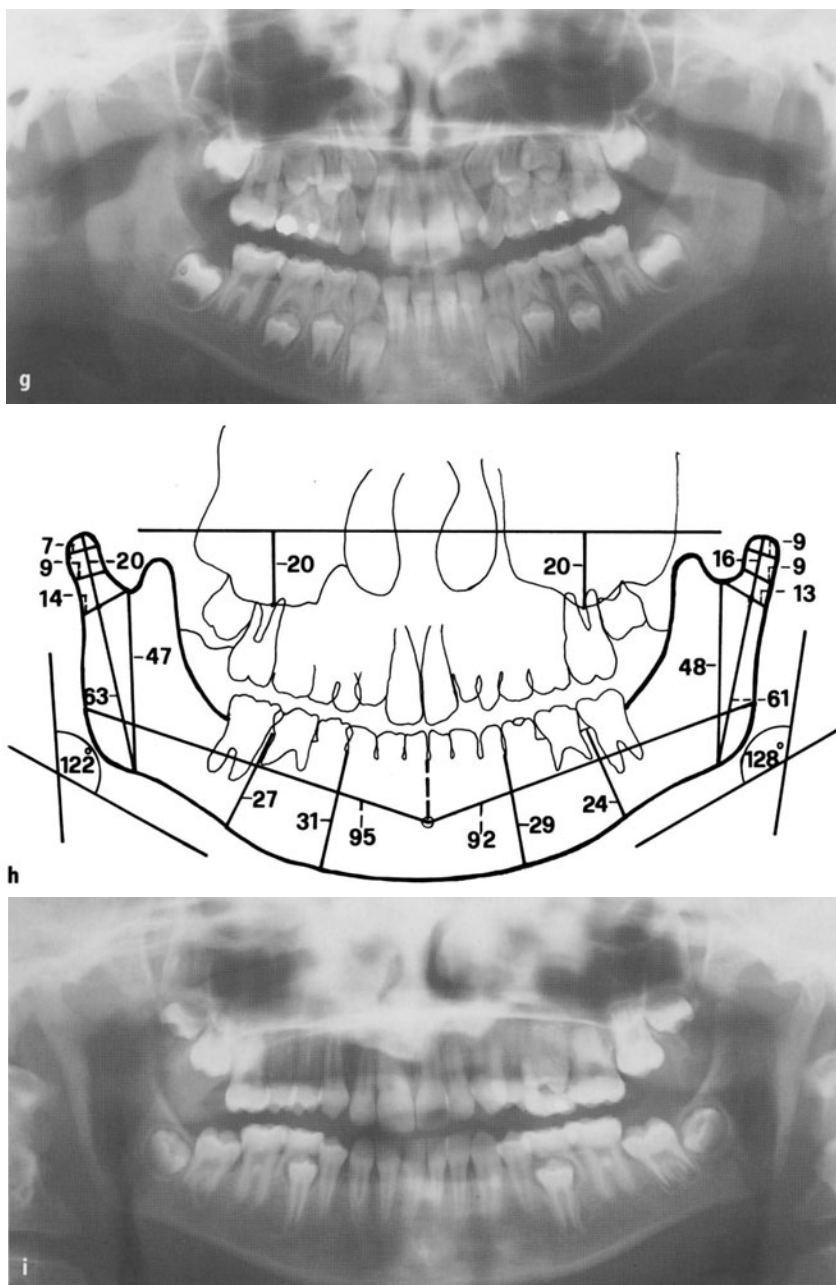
Unilateral hypoplasia of the condyle of uncertain aetiology. a, b At the age of 8 years a slight facial asymmetry is noticeable and the midline of the lower teeth is to the left by 2 mm. c, d At the age of 11 years the asymmetry of the face and of the occlusion is more pronounced. e, f At age 13 years the girl's appearance now clearly shows the consequences of hemimandibular hypoplasia, including an oblique occlusal plane and an ipsilateral hypoplasia of the zygomatic complex. g The panoramic view at age 8 years does not permit a clear diagnosis right away. h The measurements of the tracing of the panoramic radiograph, taken at age 8 years (Fig. 21g) detect a slight shortness of the left horizontal and ascending rami. i The panoramic view at age 11 already permits diagnosis of the signs of a slight mandibular hypoplasia on the left side
